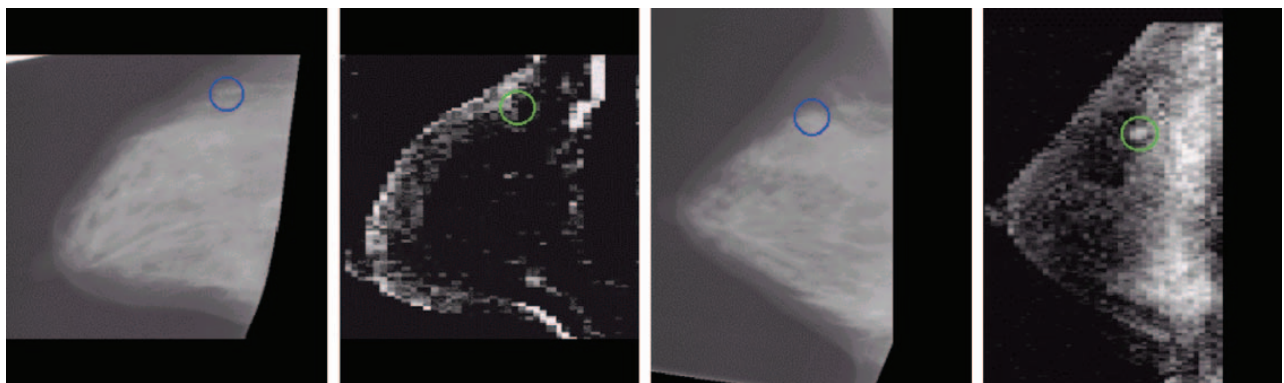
Registration results between both mammogram views and the MRI projection with corresponding region of interest location highlighted.
